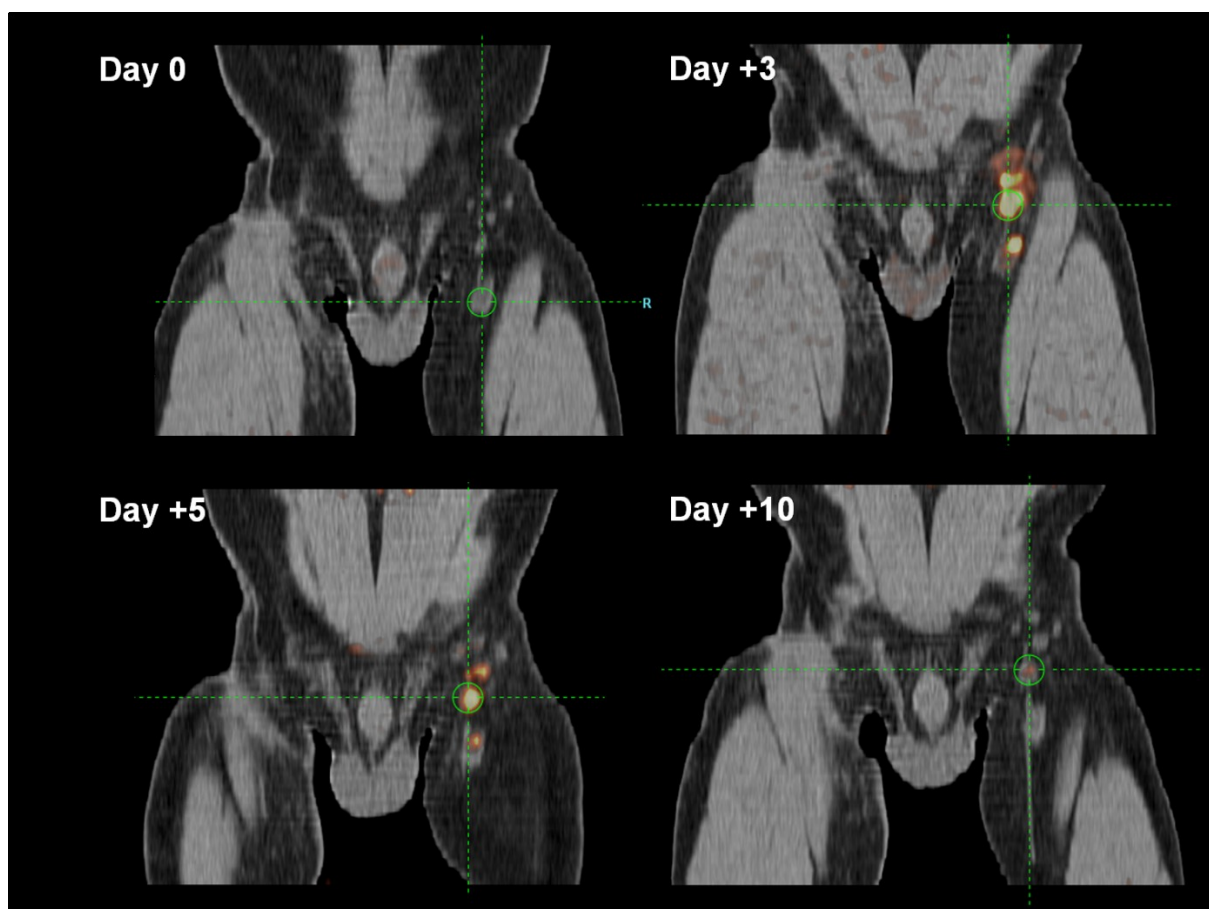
Example PET/CT scan of the dynamics of ^{18}F -FLT uptake in LN after vaccination
